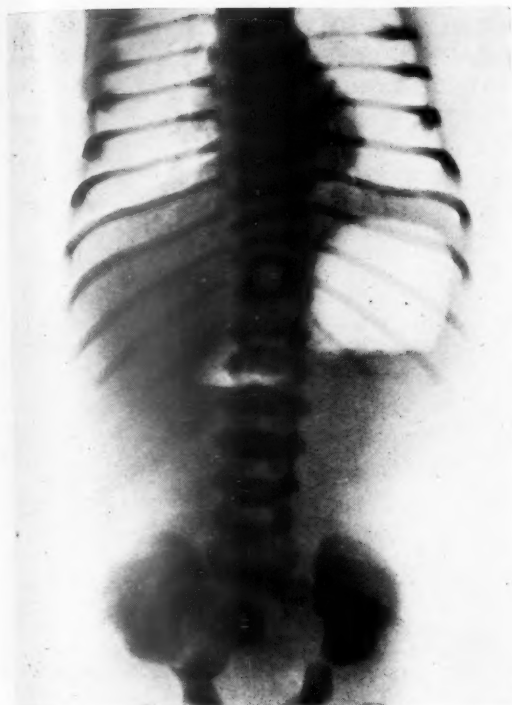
Case 2: radiograph of the abdomen (patient sitting up). The appearance is similar to Fig. 1.
